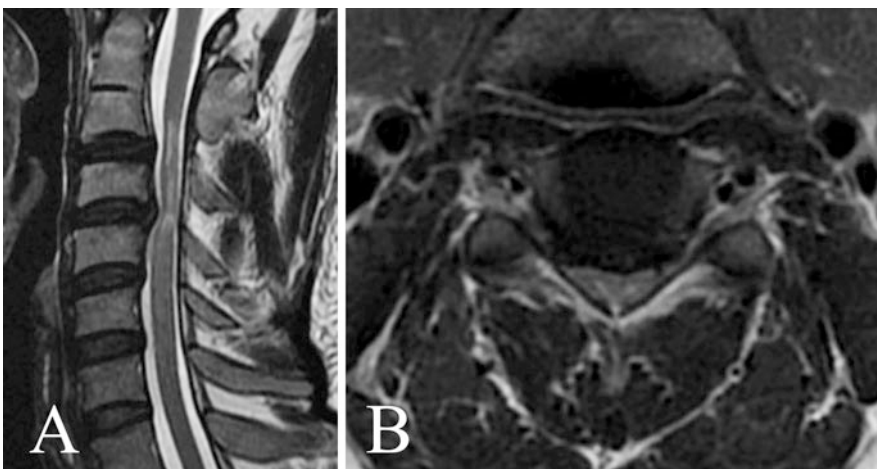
Pre-operative imaging. (a) Sagittal T2-weighted MRI demonstrating a disk bulge at C3–C4 and cord signal change. (b) Axial T2-weighted MRI
